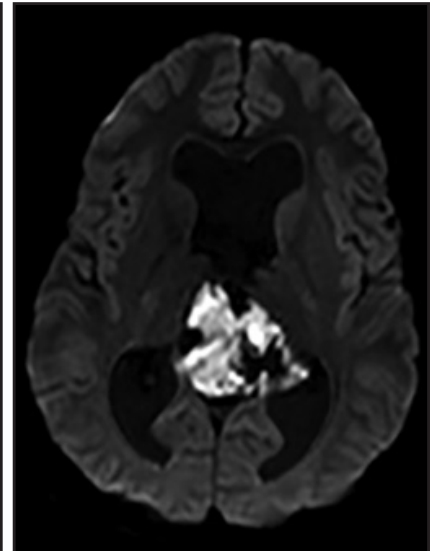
DWI axial image demonstrates diffusion restriction within a lobulated lateral ventricle midline mass.
